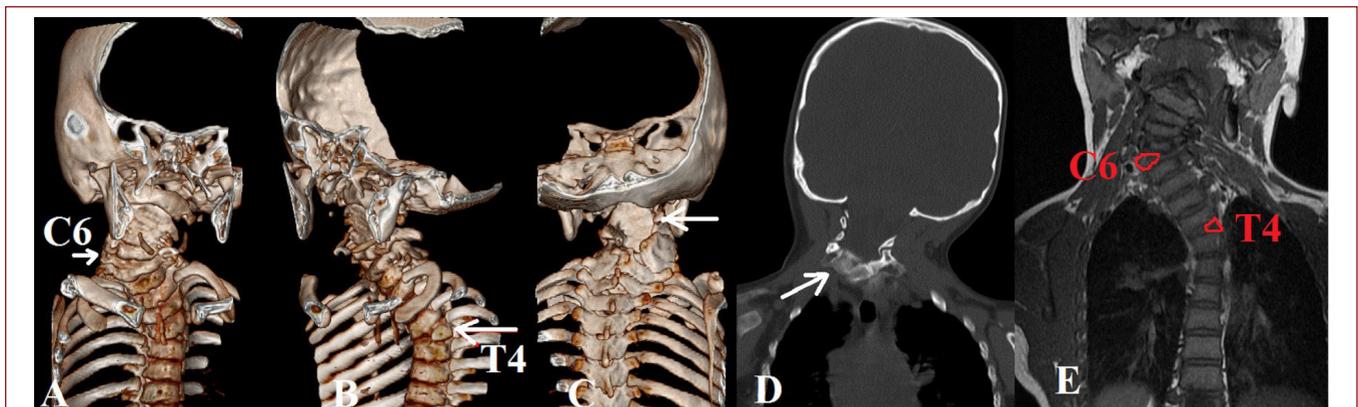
a) 3-CT image of C6 hemivertebra, b) 3-CT image of T4 hemivertebra, c) 3-CT image of posterior defect in posterior elements between C1–6, d) Coronal CT image of C6 hemivertebra e) Coronal MRI of C6 and T4 hemivertebrae.
